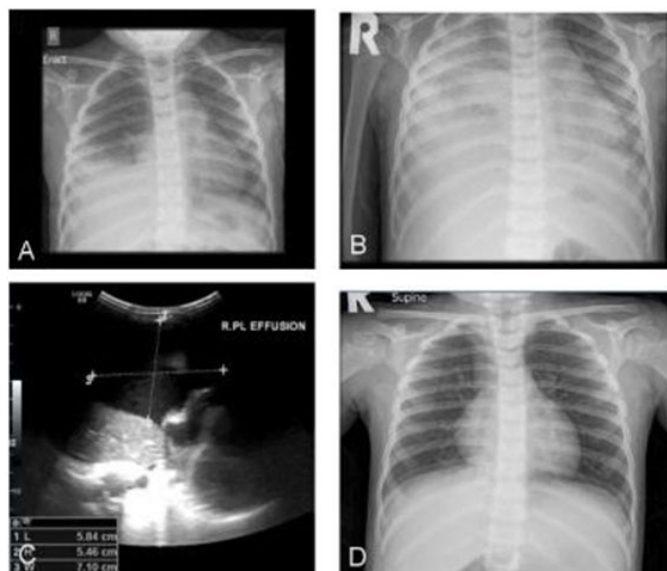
(A) Initial chest X-ray showing opacification of the right basal lobe. (B) Repeated chest X-ray showing extension of consolidation up to half of right mid zone and right pleural effusion. (C) A chest ultrasound showed moderate-to-large simple right pleural effusion. (D) Chest X-ray at 2-month follow-up reveals clear lungs.
